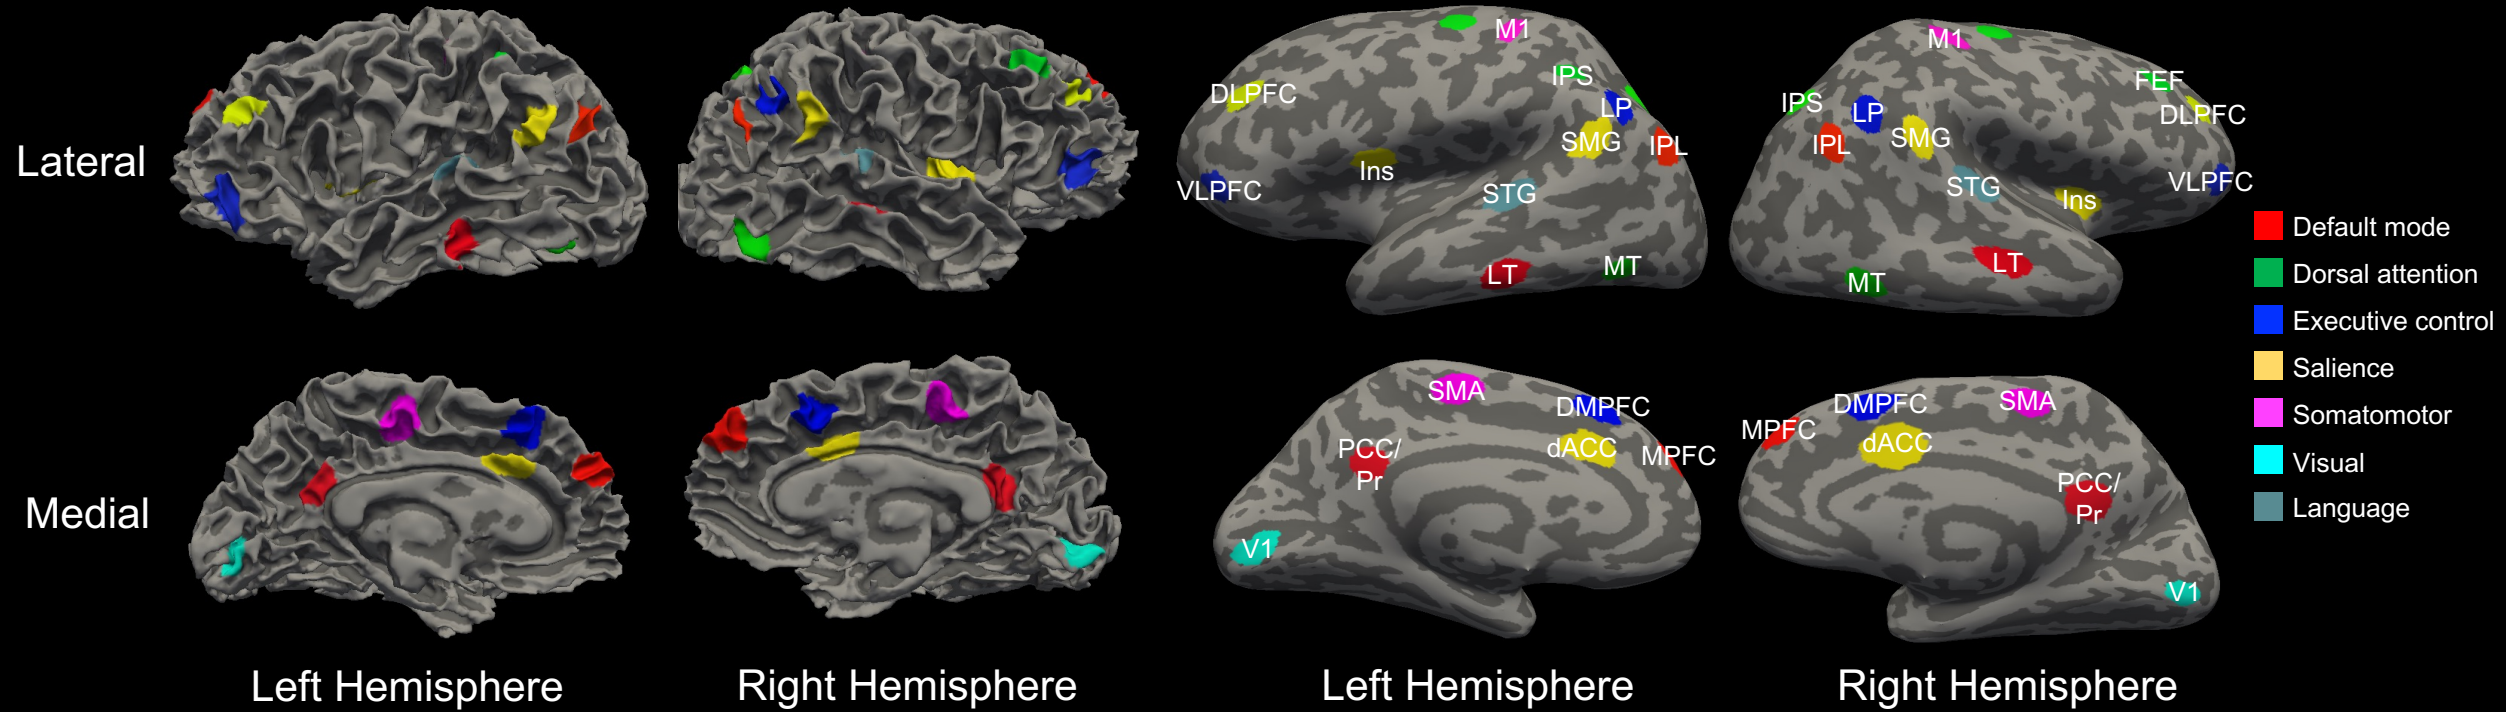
Network Nodes for Resting-state MRI Functional Connectivity Analysis.
